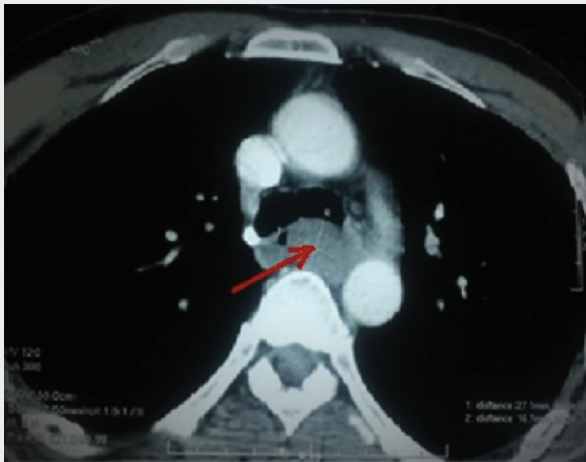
A cross section of contrast enhanced CT scan showing a tissue lesion of visceral compartment (red arrow), measuring 80X32X16 mm, well limited without signs of infiltration or associated lymphadenopathy.
